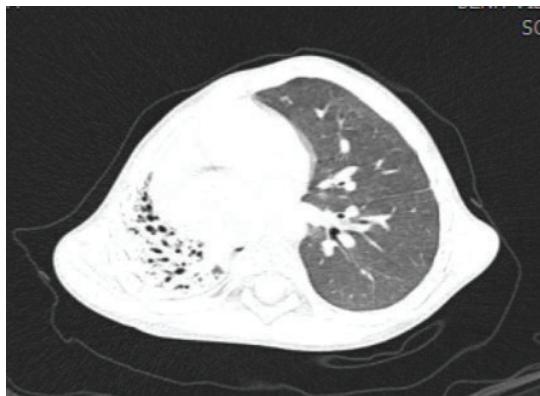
Chest CT scan in 24 October 2019 (atelectasis of the right lung: black arrow)
